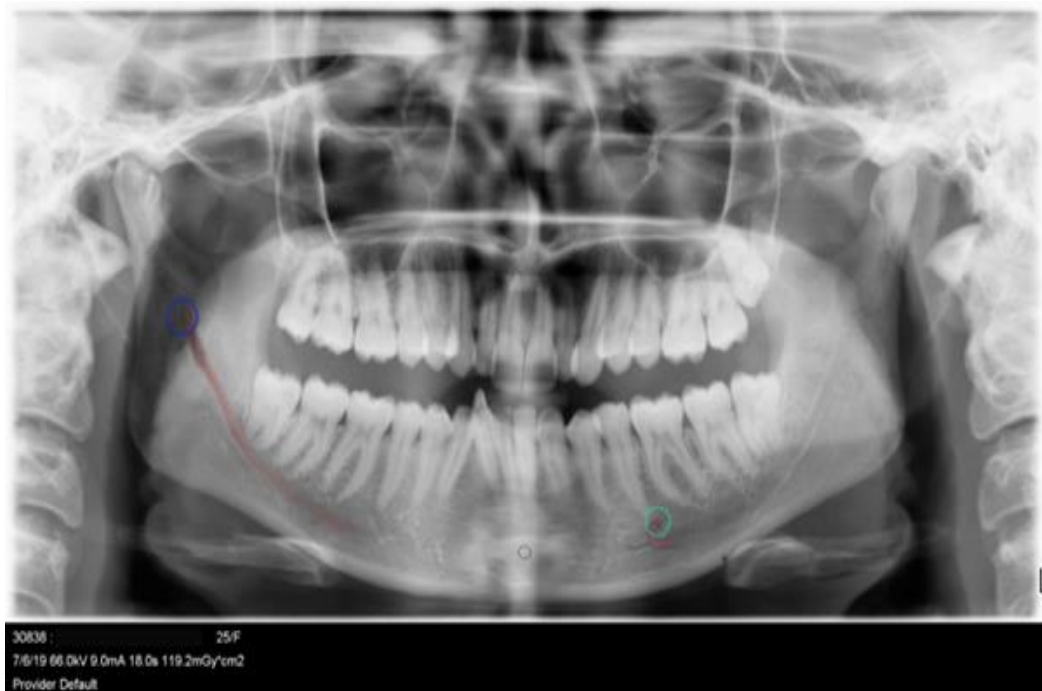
Image represents the Orthopantomographic radiograph showing the presence and visibility of the lingual foramen.
